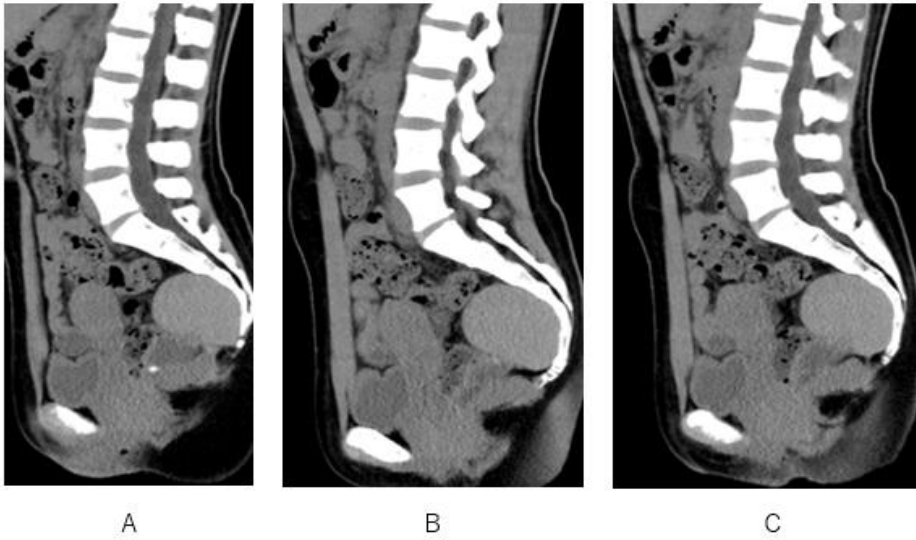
A multi-cystic lesion composed of a homogeneous iso-attenuation cyst (A-C), low-attenuation cysts (A-C) with calcification (A) is depicted between rectum and sacrum bone on pelvic CT(A-C).
